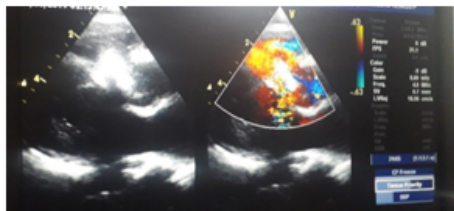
Post op echocardiography suggestive of device in situ
